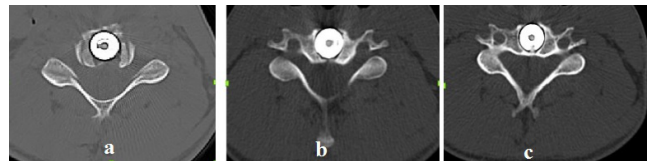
a) Postoperative 1st week b) Postop 4th month and c) Postop 4th year axial CT scan.
